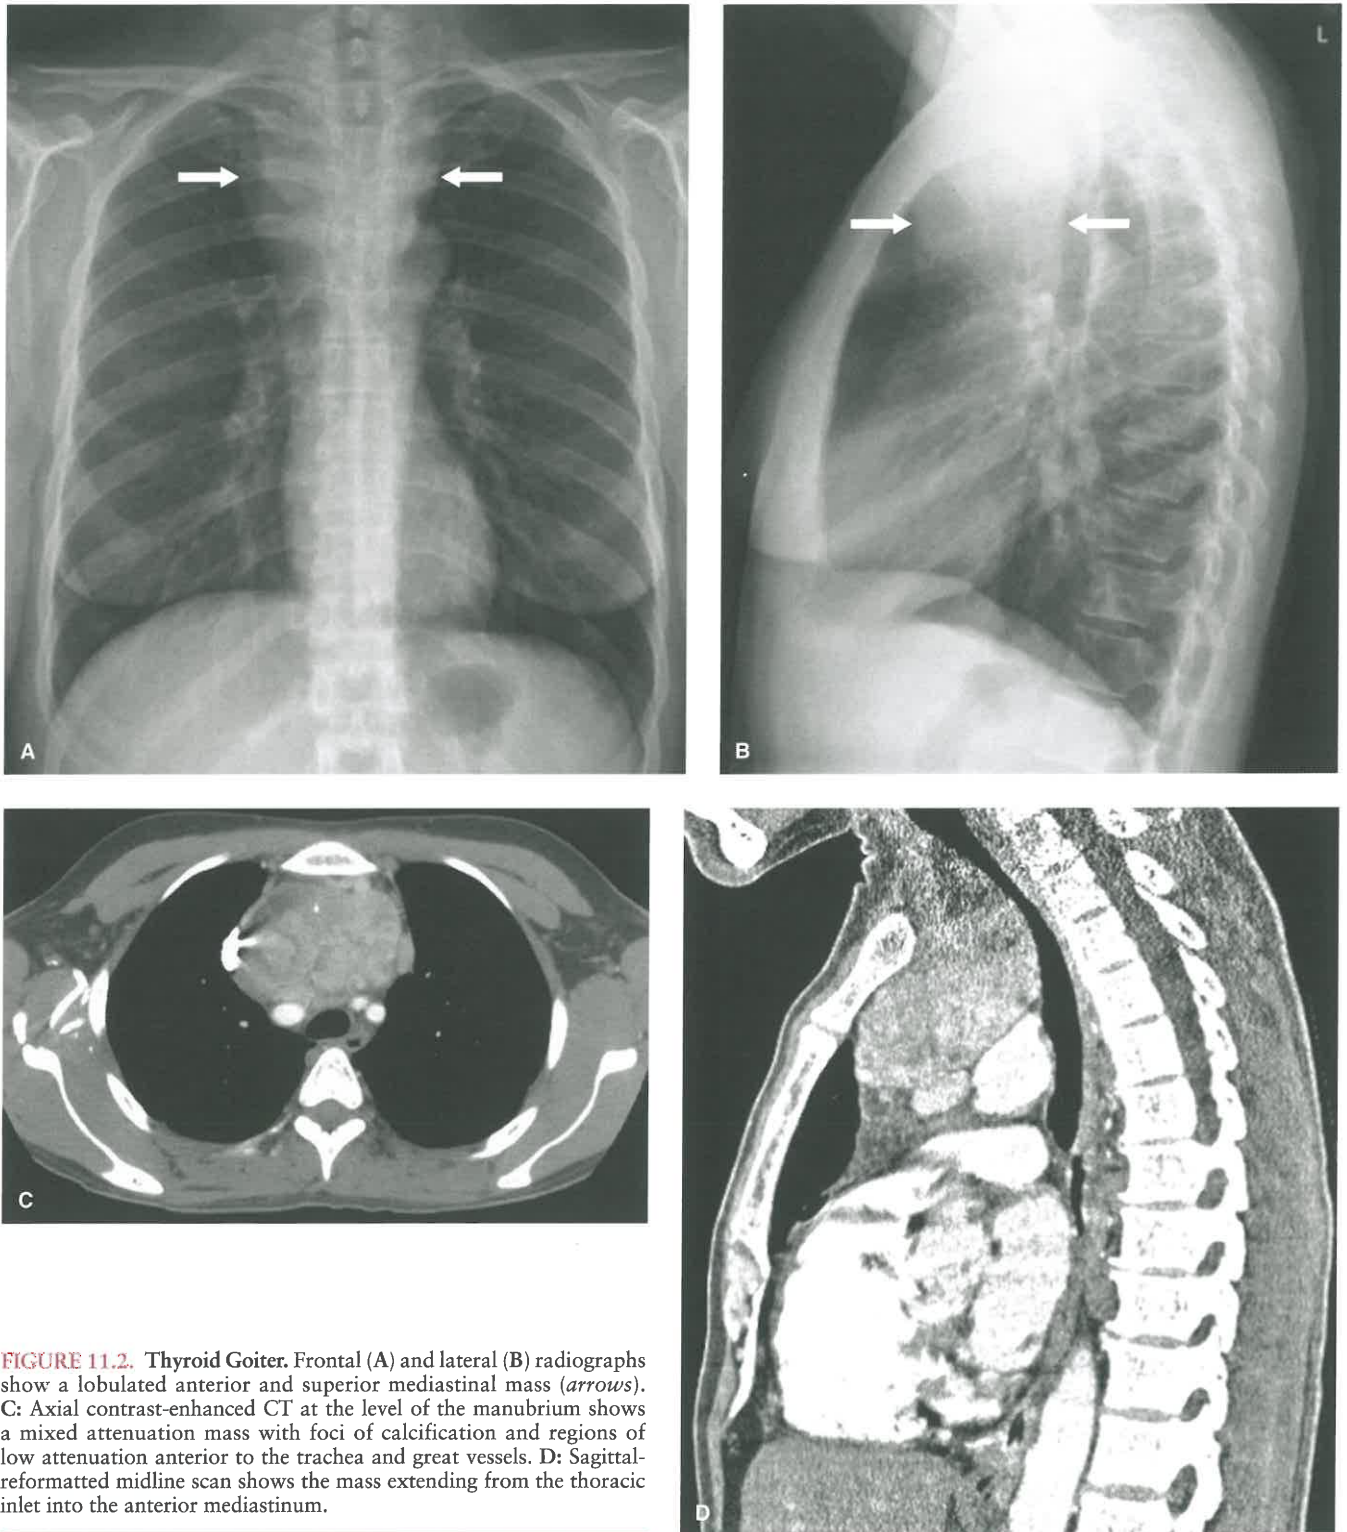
Thyroid Goiter. Frontal (A) and lateral (B) radiographs show a lobulated anterior and superior mediastinal mass (arrows). C: Axial contrast-enhanced CT at the level of the manubrium shows a mixed attenuation mass with foci of calcification and regions of low attenuation anterior to the trachea and great vessels. D: Sagittal-reformatted midline scan shows the mass extending from the thoracic inlet into the anterior mediastinum.
